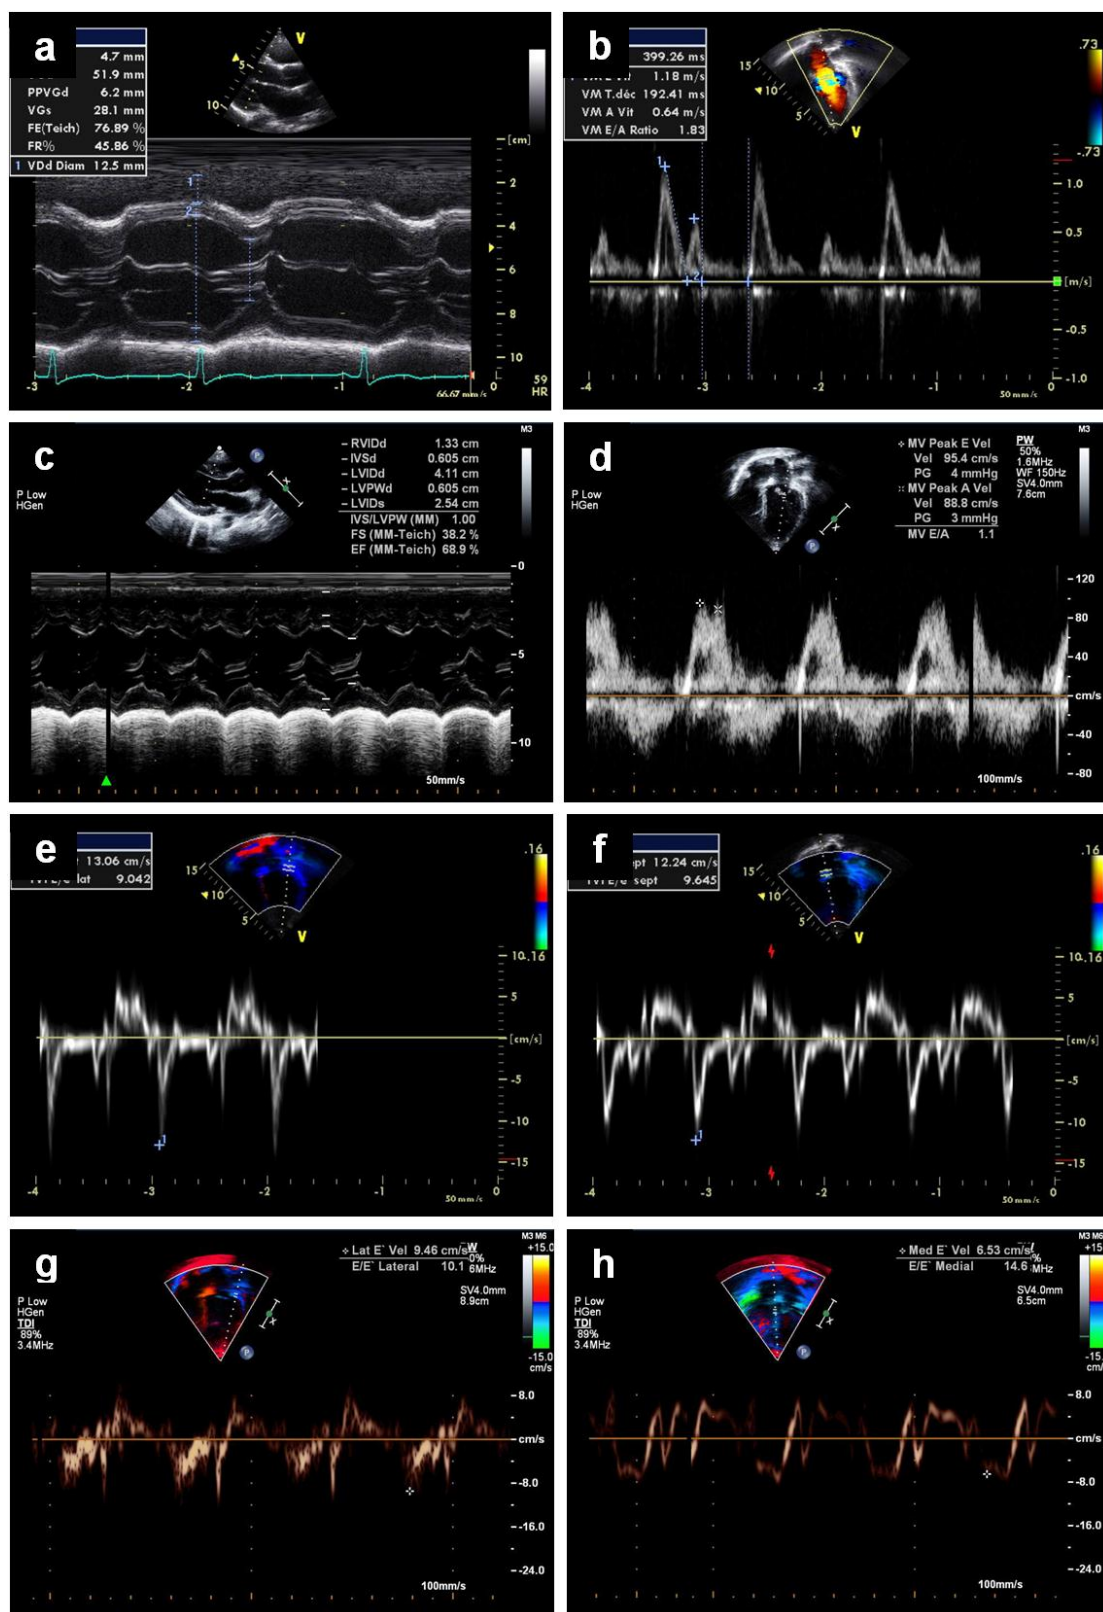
In this patient with normal myocardial systolic and diastolic function (a and b), features of diastolic dysfunction following doxorubicin chemotherapy are evidenced by mitral inflow velocity fusion of early and late phase filling (c and d). Diastolic function was also evaluated by tissue Doppler analysis (E/E' ratios) of the septal and lateral walls of the left ventricle (e and f), as demonstrated in this patient with reduced left ventricle relaxation leading to increased E/E' ratios (g and h). a) Systolic function (ejection fraction 76.9%). b) Mitral inflow (E/A = 1.83). c) Preserved normal systolic function (ejection fraction 68.7%). d) Compromised mitral inflow (E/A = 1.1) e) Normal lateral wall relaxation with E/E' = 9.04. f) Normal septal wall relaxation with E/E' = 9.64. g) Reduced lateral wall relaxation with borderline E/E' = 10.1. h) Reduced septal wall relaxation with increased E/E' = 14.6.
